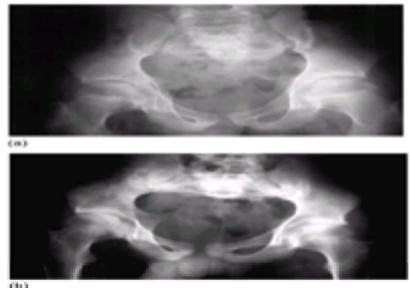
(a) Radiograph of pelvis in a 14-year-old boy demonstrating normal sacroiliac joints. He was initially diagnosed as juvenile chronic arthritis. (b) Radiograph of the same patient after 4 years of disease activity. Note the sclerosis and erosion of the sacroiliac joints. The patient did not specifically complain of back pain but has limited lumbar flexion on Schober testing.
